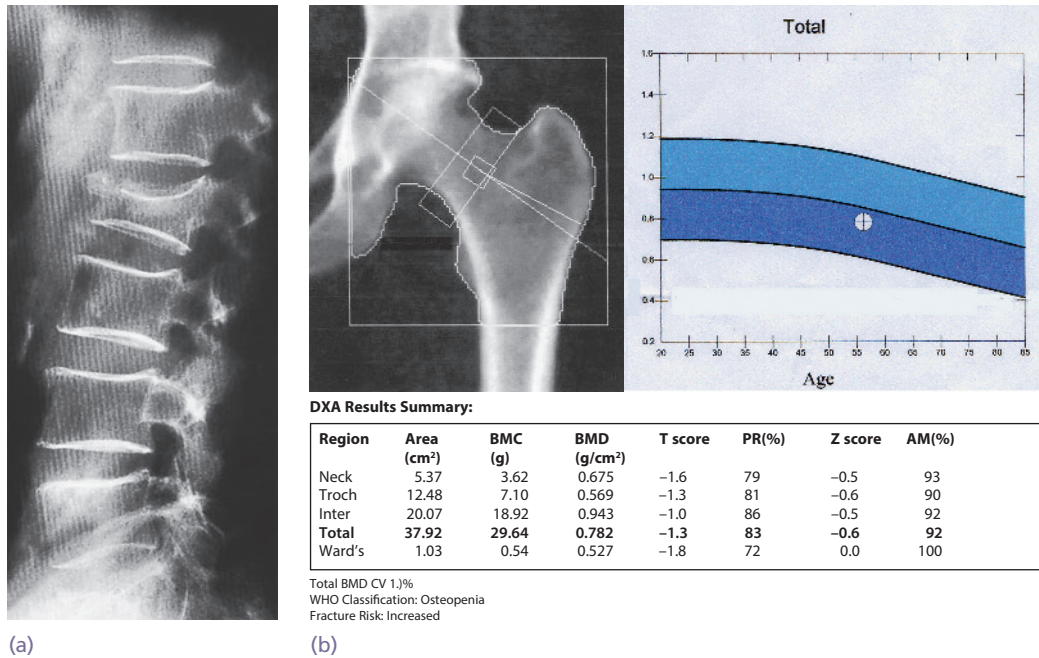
Measurement of bone mass (a) X-ray of the lumbar spine shows a compression fracture of L2. The general loss of bone density accentuates the cortical outlines of the vertebral body end-plates. These features are characteristic of diminished bone mass, which can be measured accurately by dual energy X-ray absorptiometry. (b) DXA scan from another woman who attended for monitoring at the onset of the menopause.
